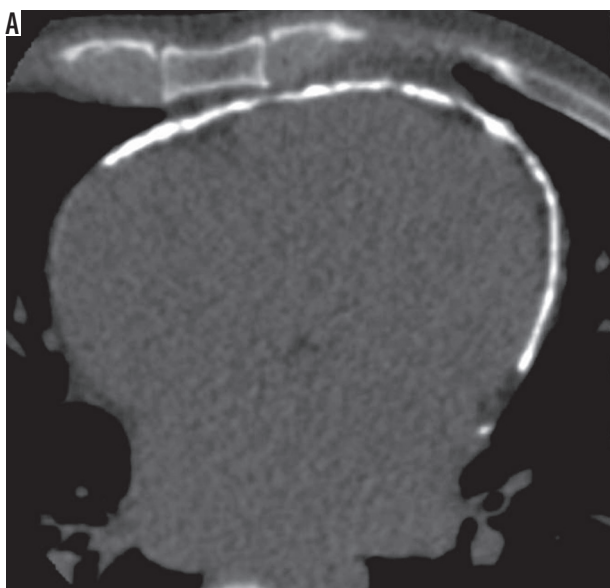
A) Plain (B) post-contrast axial computed tomography image showing pericardial calcification
